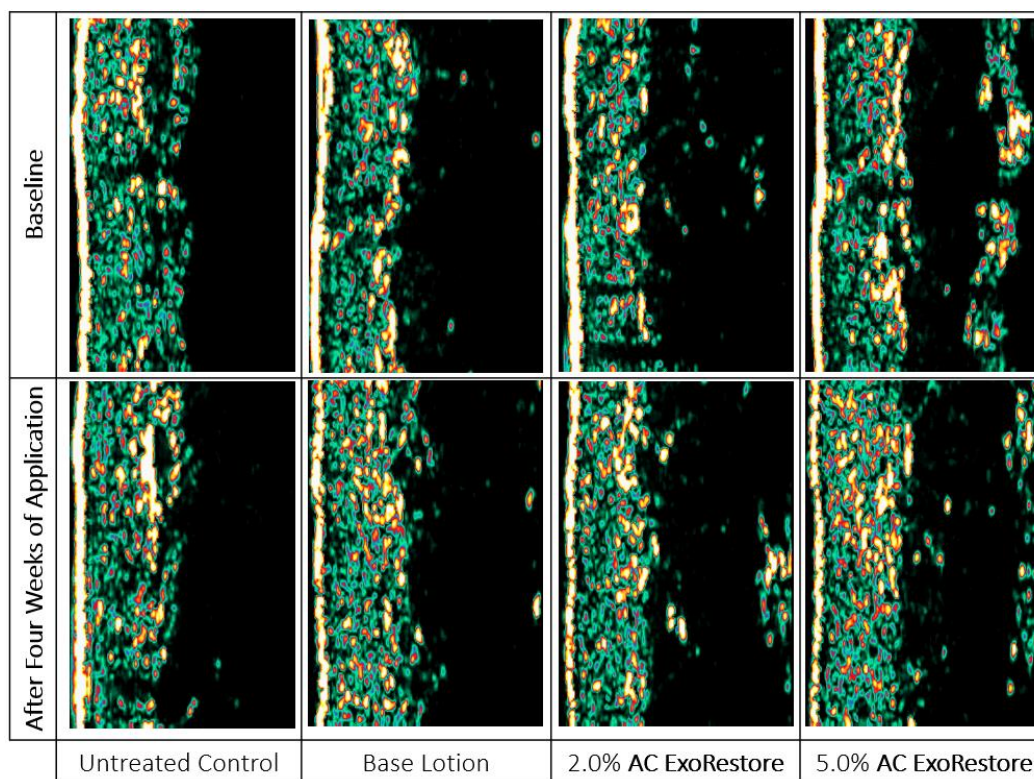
Participant Ultrasound Images of Each Test Site at Baseline (Top) and After Four Weeks (Bottom) of 2.0% and 5.0% AC ExoRestore.
